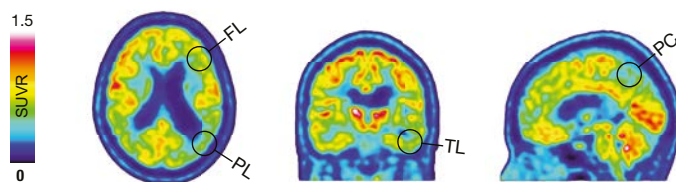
[^{18}F]FDG PET scan in a patient with AD dementia; circles indicate areas typically showing hypometabolism in AD, including the temporal (TL) and parietal (PL) lobes, as well as the precuneus (PC). Involvement of the frontal lobe (FL) can be seen later on the disease course, while metabolism within the occipital lobe is typically preserved.
